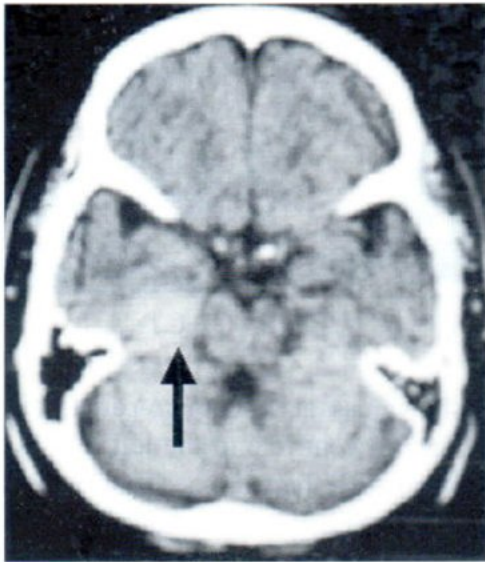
A Non-contrast CT shows ill defined mass at right petrous ridge.
